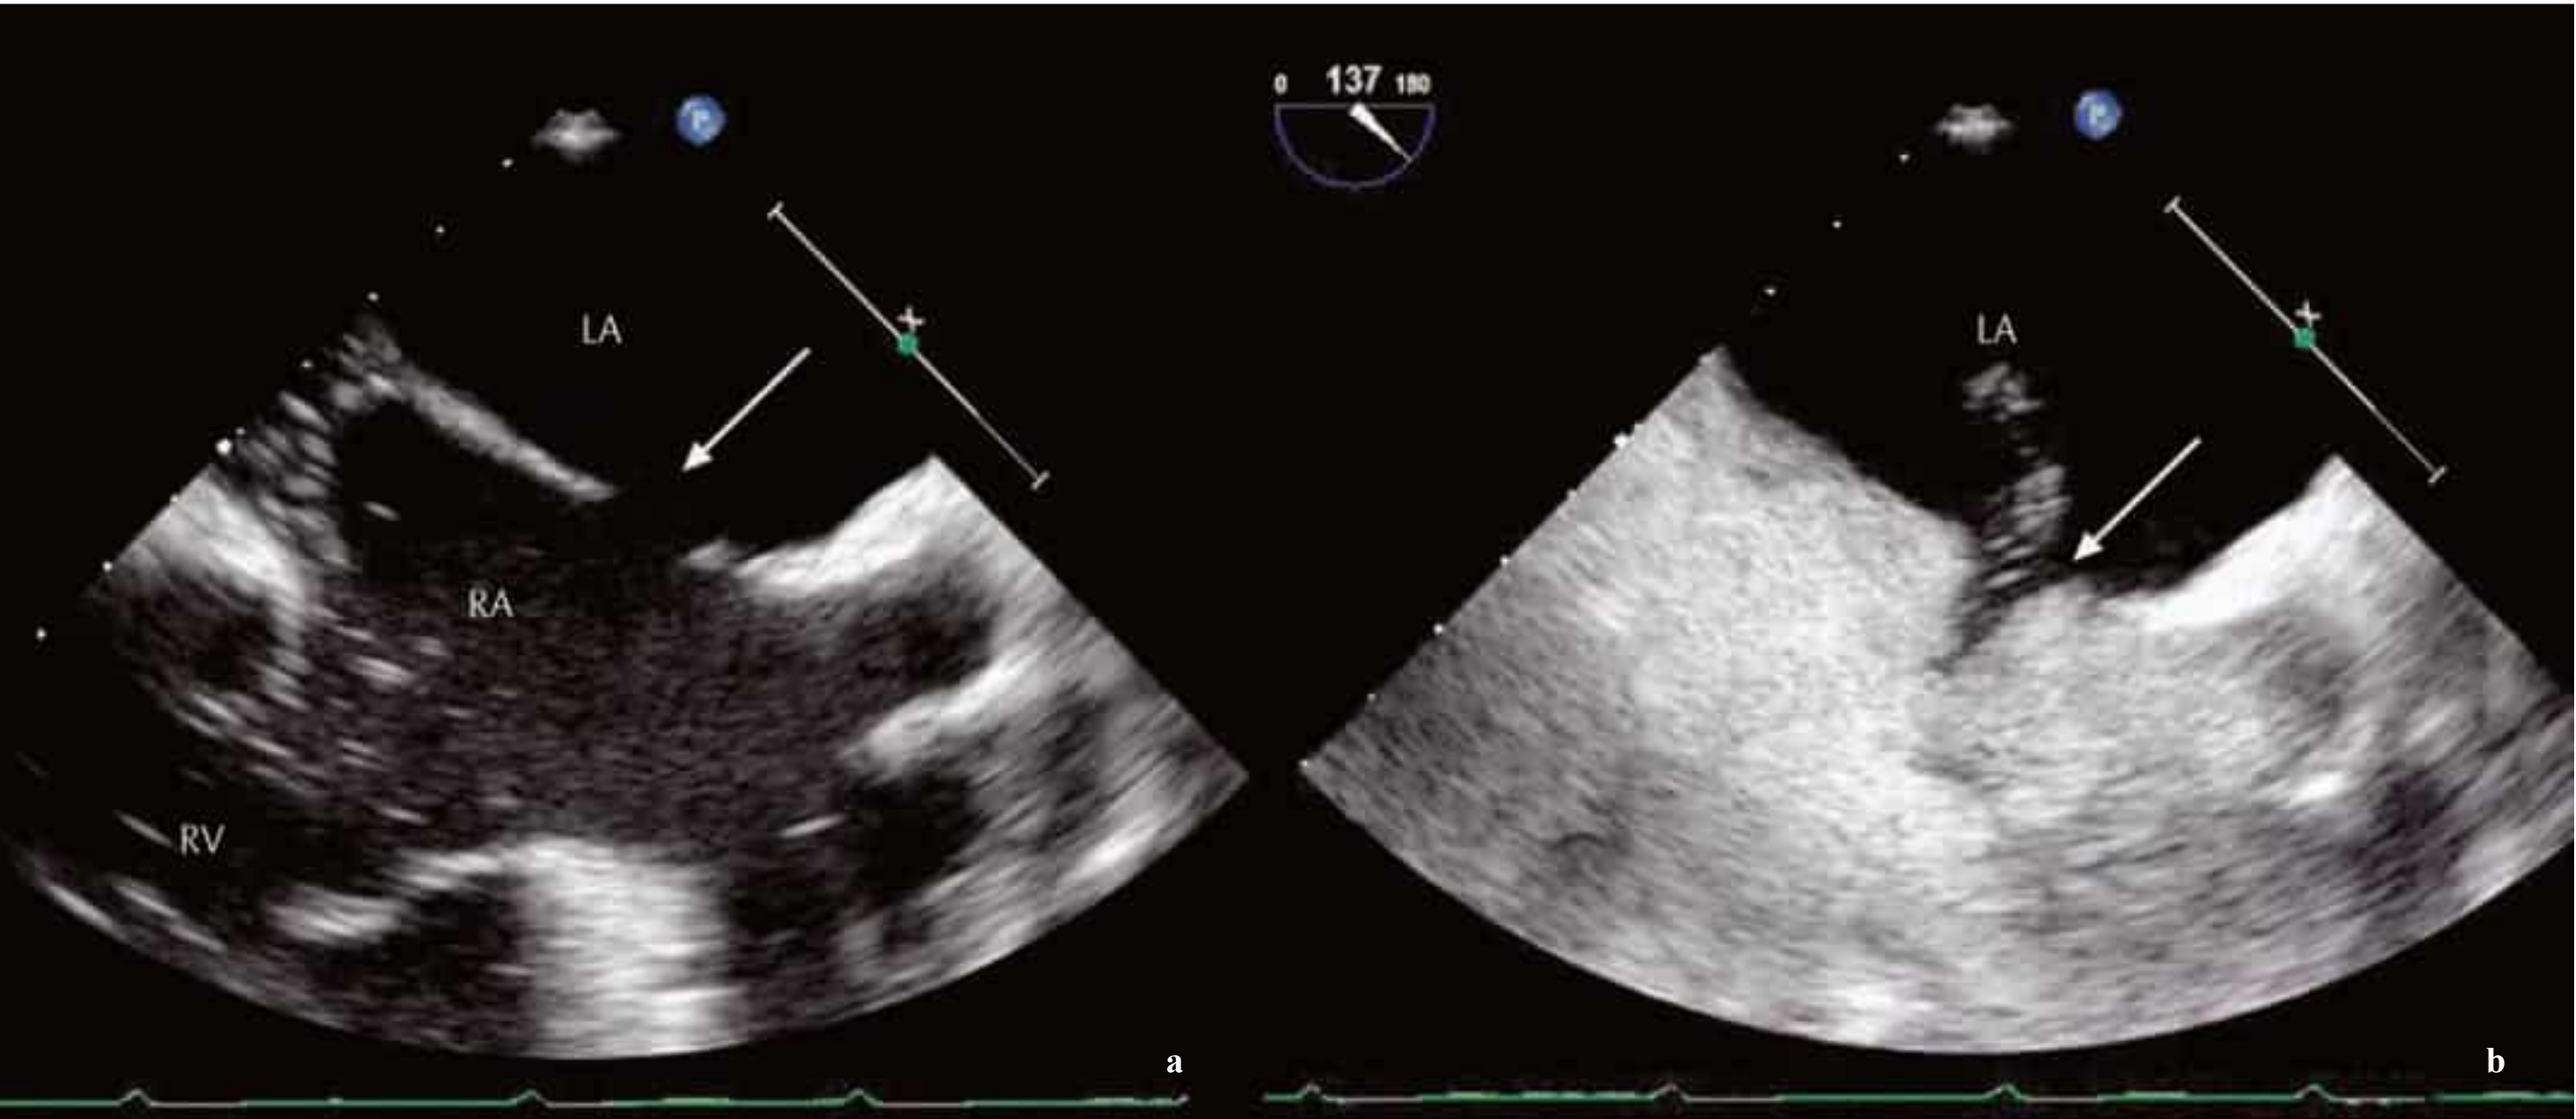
a, b Transesophageal echocardiography of ASD II (arrow).
